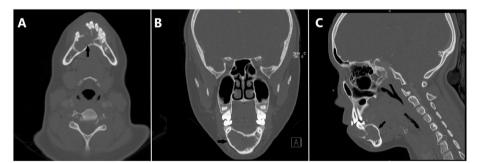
CT scan of case 1. a Axial view. b Coronal view. c Sagittal view. Black arrows show the lesion
